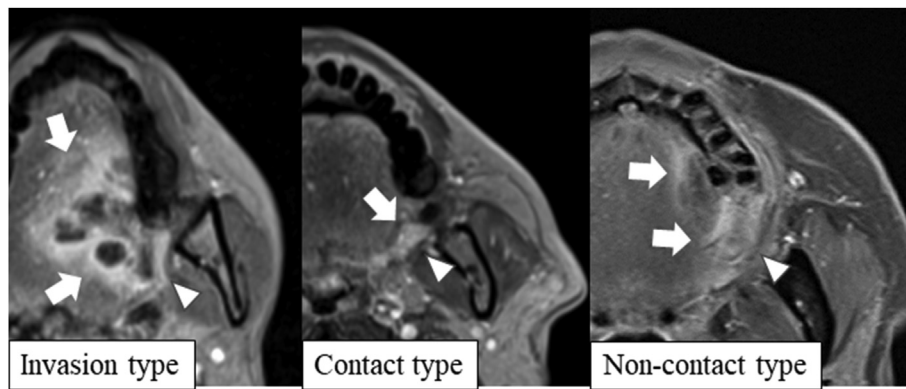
Type of pterygomandibular raphe (shown in enhanced magnetic resonance images). Non-contact type: 54-year-old female; maxillary gingival cancer (T4aN0M0) (right). Contact type: 70-year-old male; mandibular gingival cancer (T2N0M0) (center). Invasion type: 23-year-old male; tongue cancer (T4aN2bM0) (left). White arrow: Tumor; white triangle: pterygomandibular raphe.
